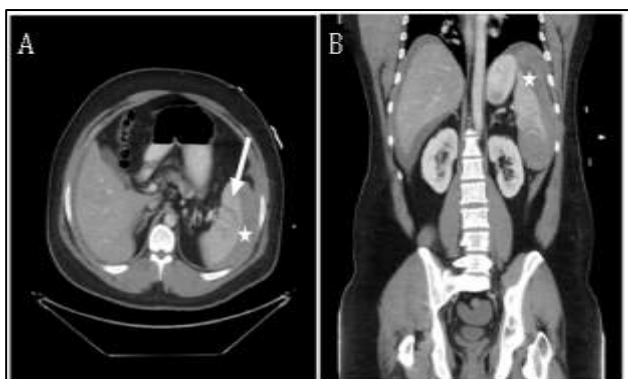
CT abdomen/pelvis obtained on day of admission. (A, B) Axial and coronal views of our patient's grade III splenic laceration (white arrow) with subcapsular hematoma and surrounding hemorrhage (stars) tracking around the spleen and liver and into the pelvis; no evidence of active extravasation.
